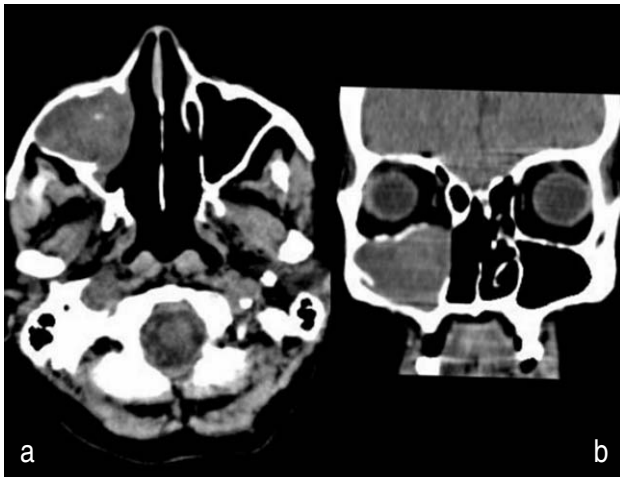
(A and B): Axial and coronal unenhanced CT scan images showing heterogenous lobulated soft tissue density lesion involving right maxillary sinus also bulging into right nasal cavity with few patchy areas of low density and foci of calcification.
